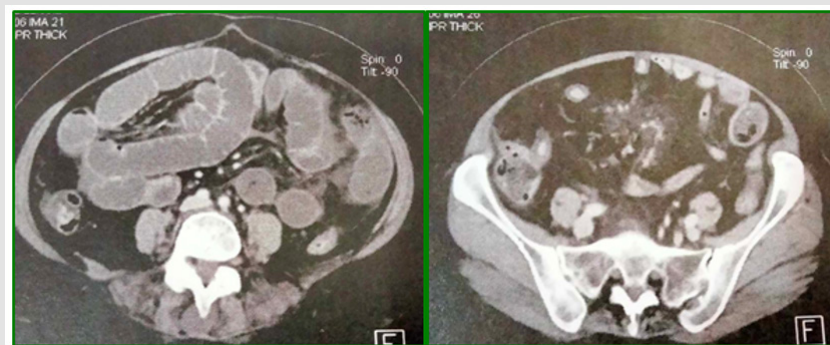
Axial sections of an injected abdominal CT, revealing severe upper intestinal obstruction associated with mesenteric thickening.
